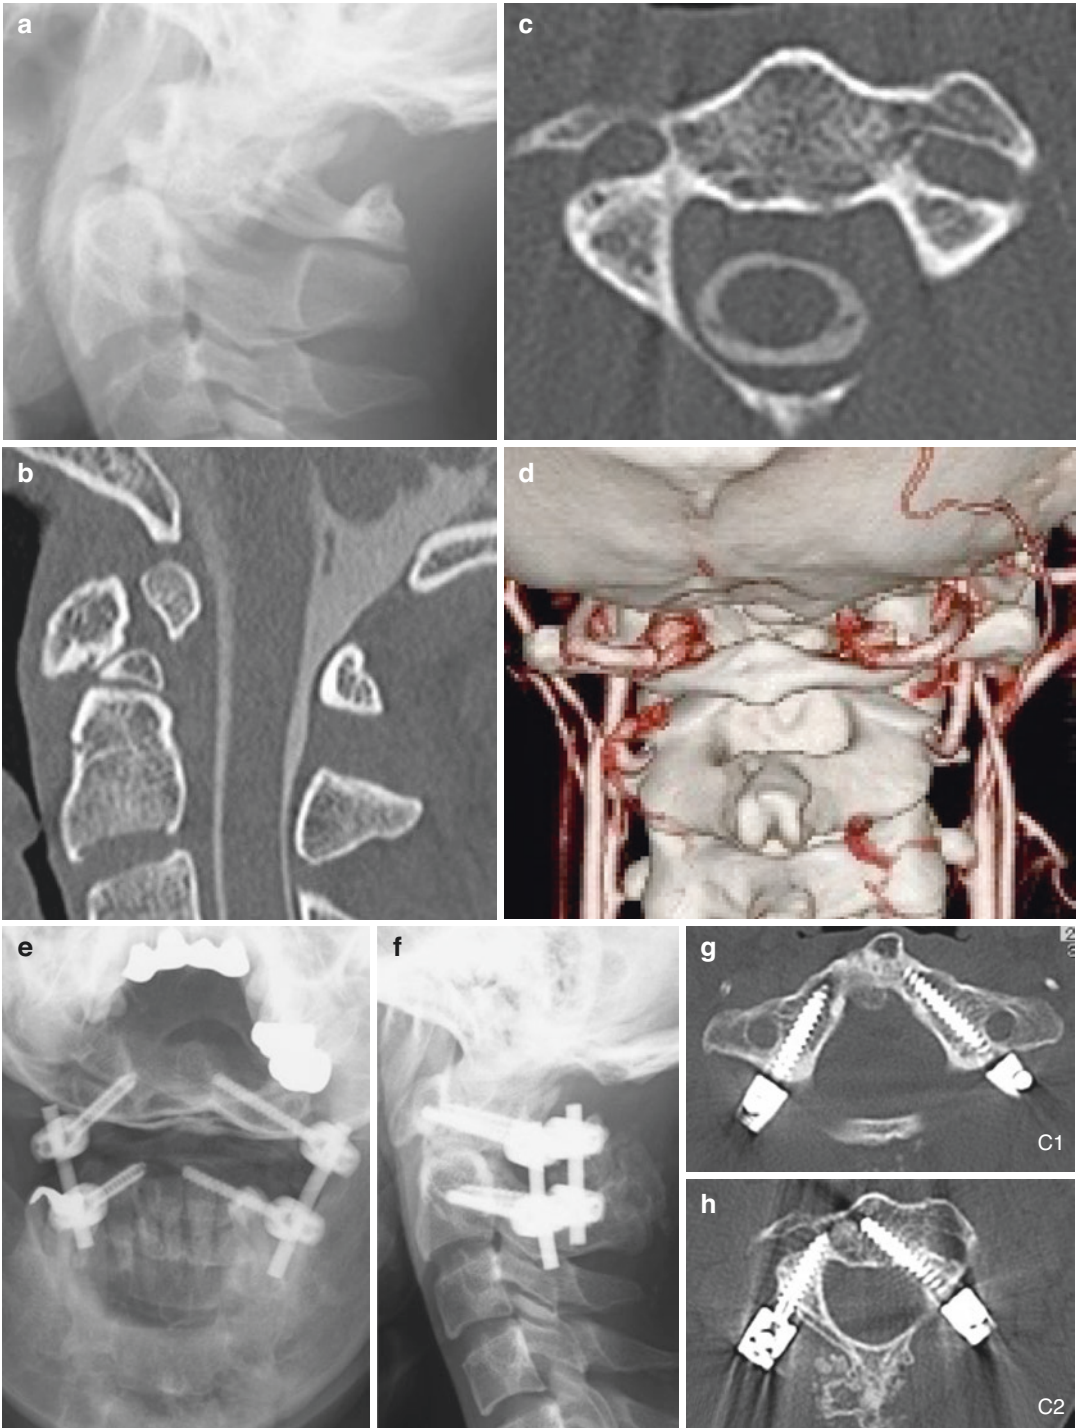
High position of vertebral artery (36-year-old male, pseudarthrosis of odontoid fracture). (a) Plain X-ray of lateral C1–C2; (b) CT-myelogram; (c) axial view of CT myelogram showed high position of vertebral artery; (d) enhanced 3D-CT angiogram. (e) Postoperatively
